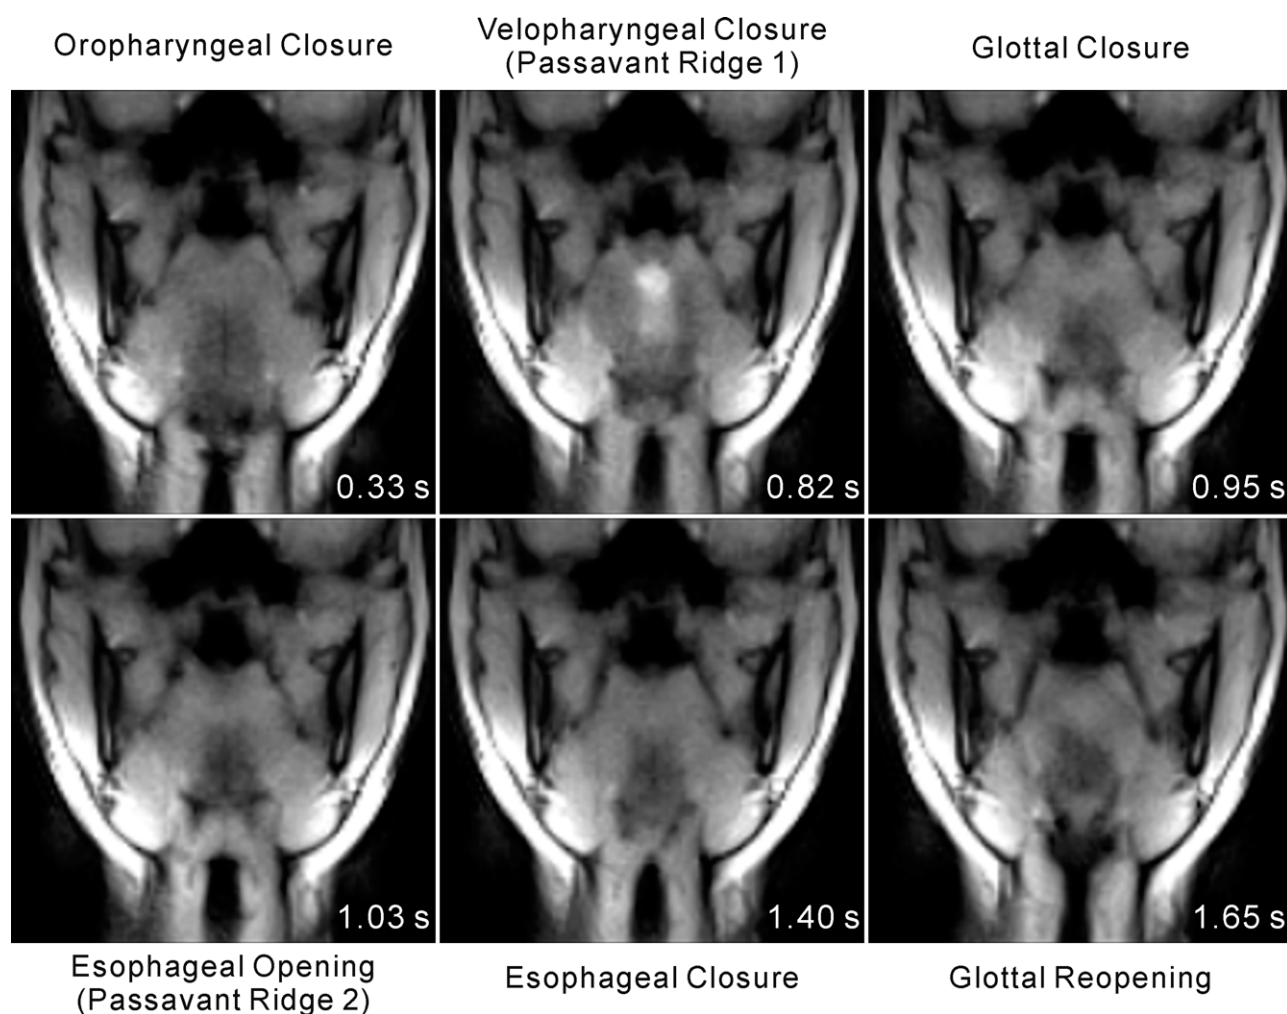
Real-time MRI of normal swallowing in a coronal plane (same subject and parameters as in Fig. 2). The images represent distinct swallowing events (relative timings as in Fig. 2) from a corresponding movie of a single swallow at 24.3 fps (see Supporting Movie 2).
